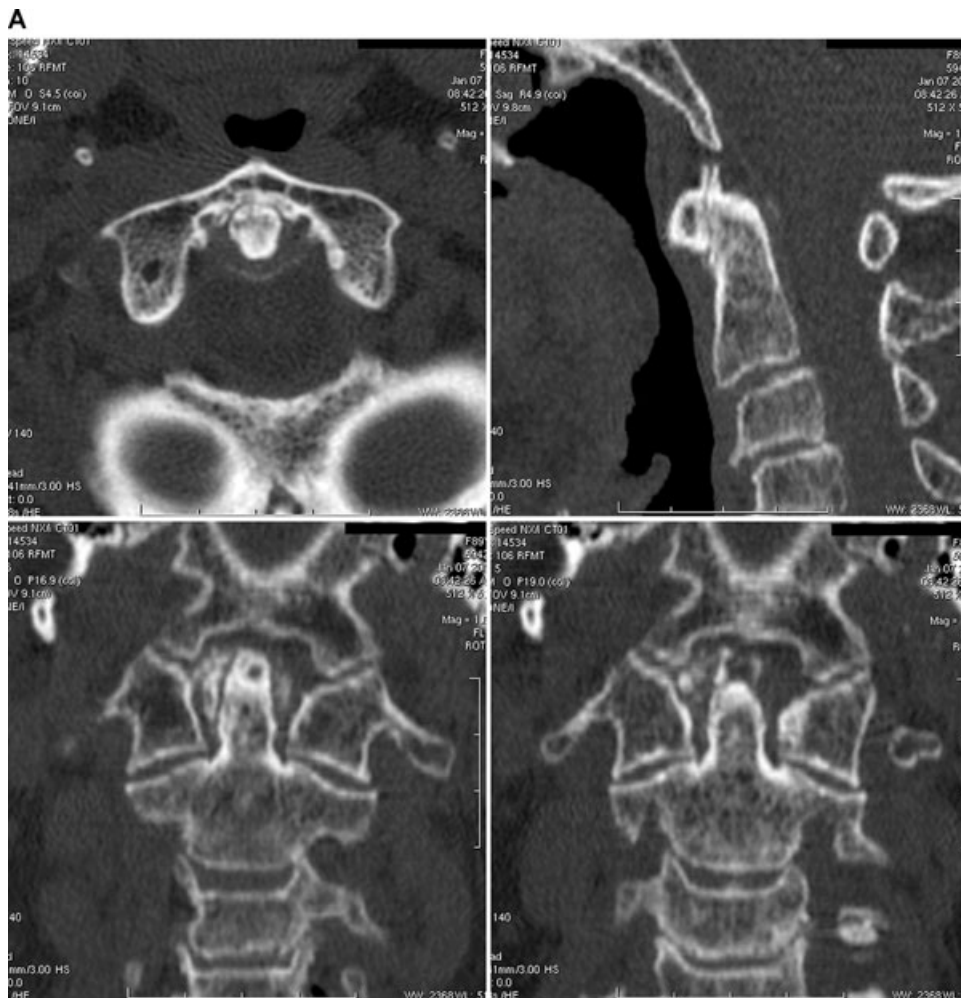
CT of the crano-cervical junction of an asymptomatic 89-year-old woman referred for preoperative evaluation of dental implants. The axial and reformatted images (A) disclose faint linear calcifications along the cruciform ligament (upper row) and crown-like calcified deposits around the odontoid process (lower row), associated with severe atlanto-axial degeneration. The volume-rendered image (B) displays these findings in a more graphical way.
